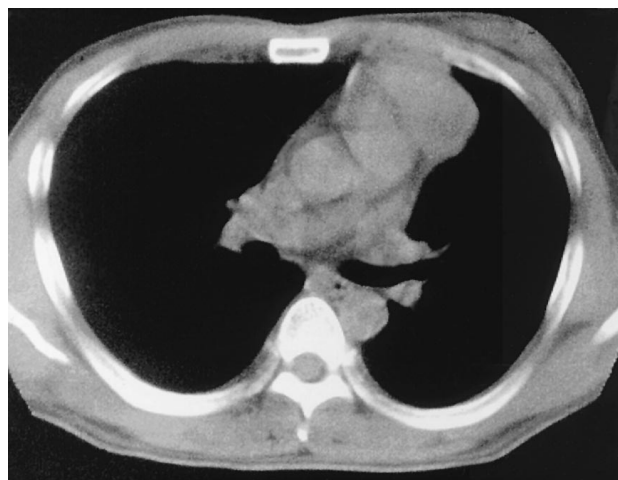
(Patient 6.) Computed tomographic scan of the chest reveals a large mass in the anterior mediastinum.
